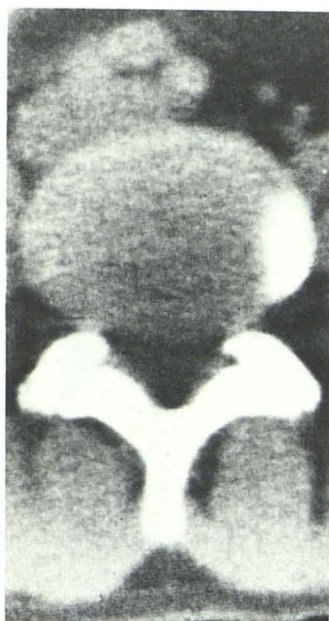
Diffusely bulging disk. Axial CT image at level of L4–5 intervertebral disk. Posterior margin of disk is convex, indicating minimal diffuse bulging, slightly greater on patient's left side than on right.
